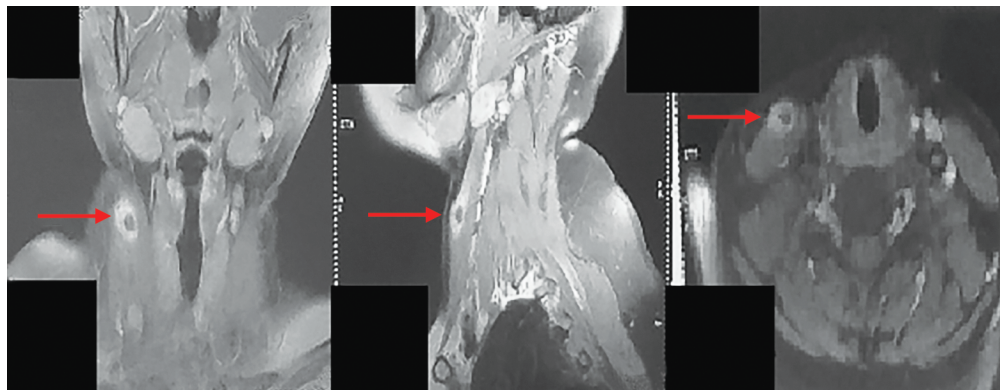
MRI neck showing swelling in SCM in coronal, sagittal, and axial planes
